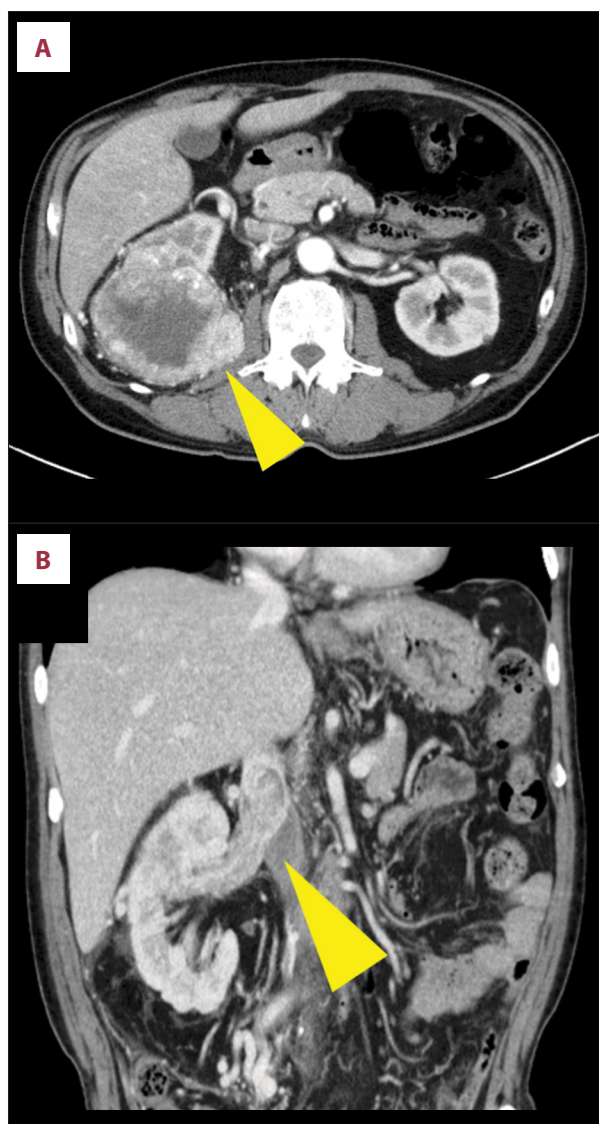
Baseline computed tomography showing clear cell renal cell carcinoma with an inferior vena cava tumor thrombus and pulmonary metastases. (A) Axial contrast-enhanced computed tomography (CT) image showing the right renal mass (arrow). (B) Coronal contrast-enhanced CT image showing a level II inferior vena cava (IVC) tumor thrombus (arrow). (C) Axial chest CT image showing multiple bilateral pulmonary metastases (arrows). These findings established metastatic renal cell carcinoma requiring initial systemic therapy.
